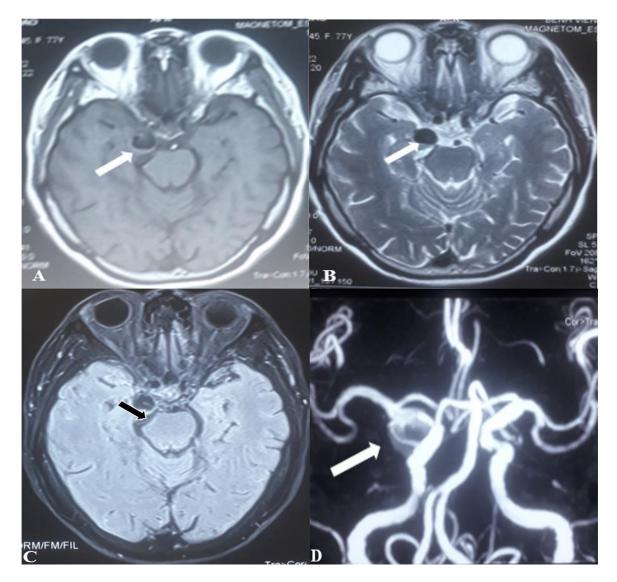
Aneurysm on brain MRI. (A, B) Aneurysm on T1-, T2-weighted images; (C) brain stem compression due to the presence of aneurysm on flair-weighted; (D) aneurysm on 3-dimensional (3D) time-of-flight (TOF).
